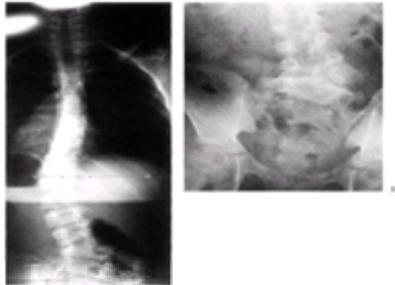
A: This adolescent patient presented with spinal deformity, with the standing PA radiograph demonstrating an obvious left thoracolumbar deformity. On more careful examination, an abnormality at the lumbosacral junction is suggested. B: A cone-down radiograph of the lumbosacral junction demonstrates a clear hemivertebra. This congenital malformation is the primary deformity, and the thoracolumbar deformity above is a compensatory curve.
